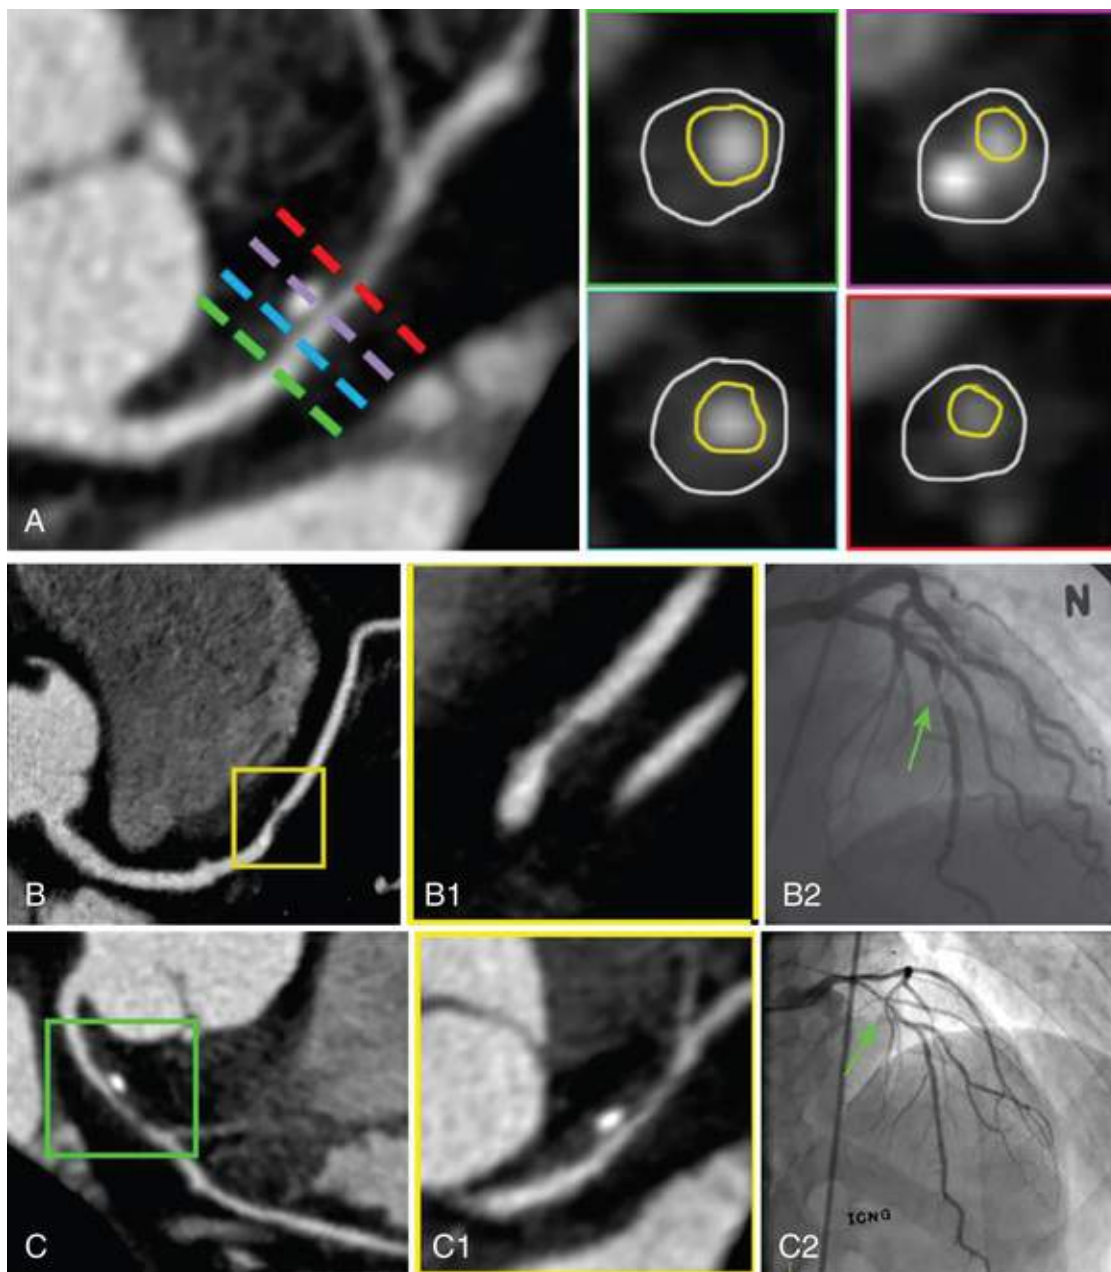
Relationship of aggregate plaque volume and coronary artery ischemia. A, Aggregate plaque volume percent (%APV) can be calculated by the ratio of the plaque area over the vessel area to the length of a coronary vessel; 1-mm cross-sectional areas are traced for vessel, lumen, and plaque areas. B, High-grade stenoses (yellow box) that are associated with low %APV (B1) are less likely to cause ischemia (B2). C, In contrast, stenoses (green box) that are associated with high %APV (C1) are more likely to produce ischemia (C2). (Modified from Nakazato R, Shalev A, Doh JH, et al. Aggregate plaque volume by coronary computed tomography angiography is superior and incremental to luminal narrowing for diagnosis of ischemic lesions of intermediate stenosis severity. *J Am Coll Cardiol* 2013;62:460-7.)
